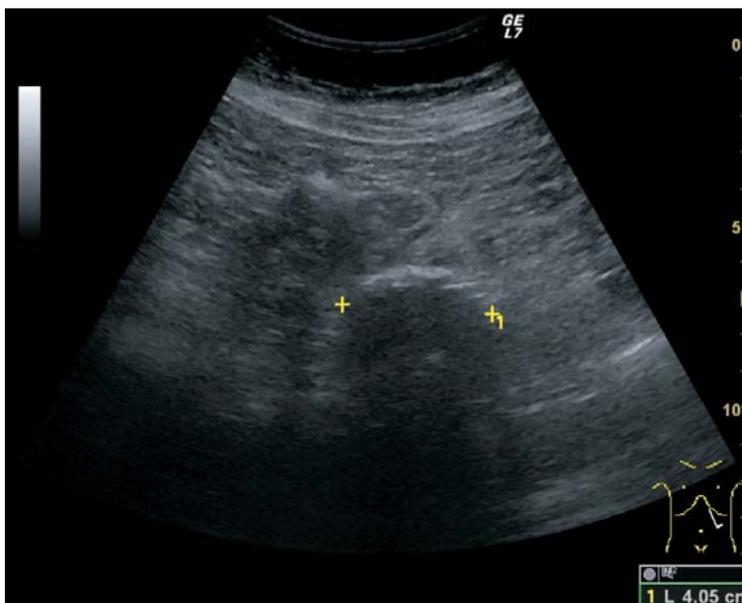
Ultrasonographic image: a cystic structure in the tail of the pancreas
